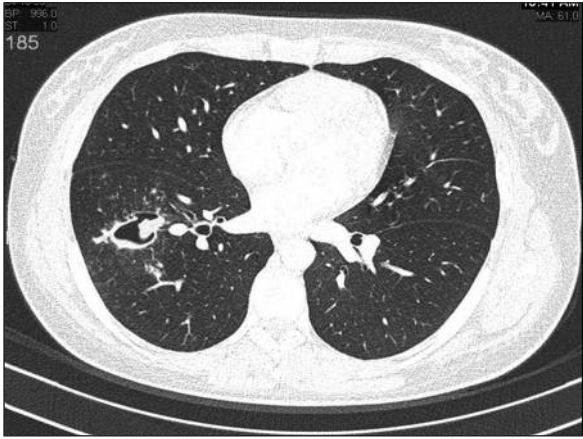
The cavitary lesion on reperforming thorax CT.
